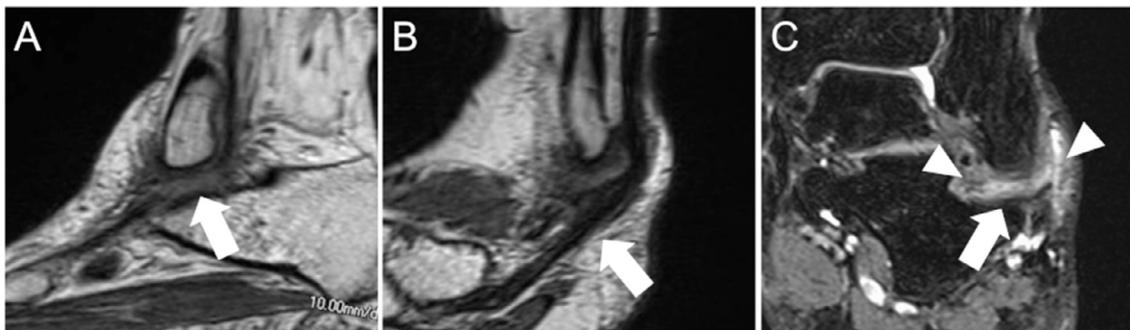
MRI proton-weighted oblique sagittal image (A) shows a signal change of the peroneus brevis tendon that is impinged between the lateral malleolus and peroneal tubercle (arrow). The peroneus longus tendon is not injured (B). In the proton density fat suppression coronal image (C), a flattened peroneus brevis tendon (arrow) and the surrounding tenosynovitis (arrowheads) are seen.
